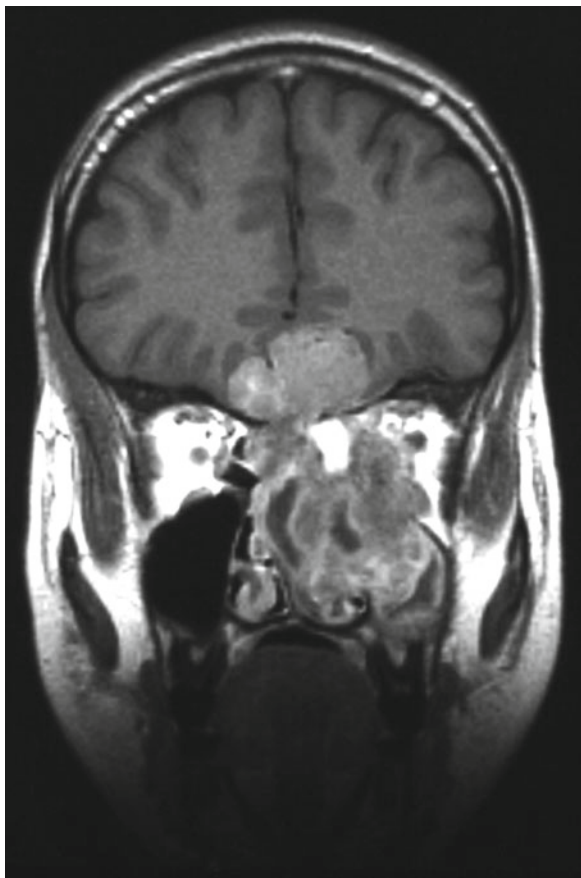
Esthesioneuroblastoma, Kadish stage C, infiltrating the orbita, the nasal and paranasal cavities, and, through the lamina cribiformis, the brain (MRI)
